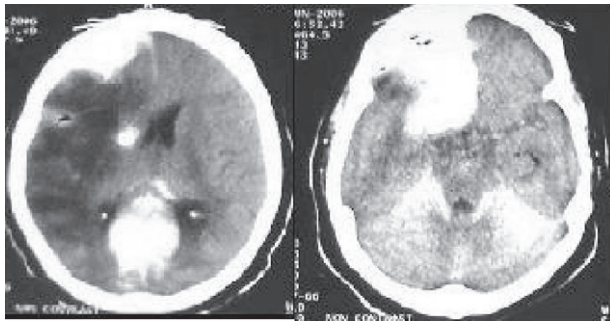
Non-contrast CT head showing hyper-density in right frontal, tentorial and interhemispheric region.
